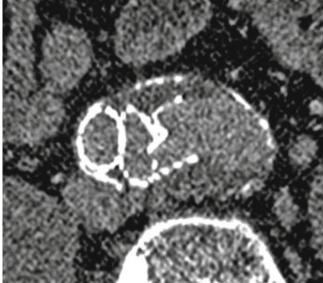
Corresponding CT images of the detached left iliac limb
